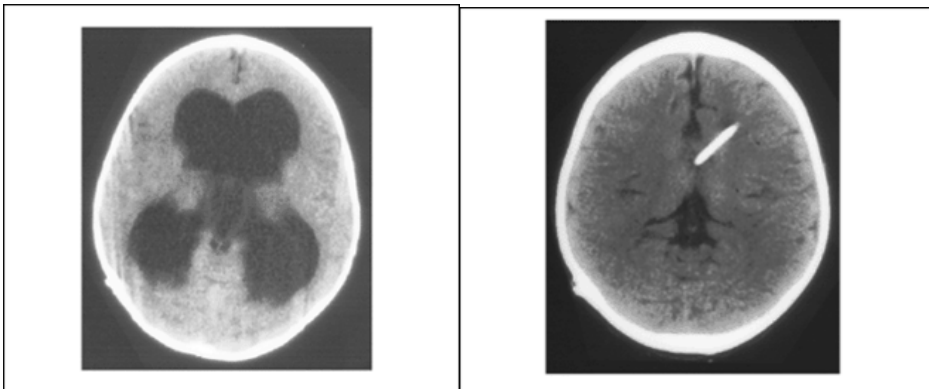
Before and after MRI images of patient with hydrocephalus treated with a shunt.
